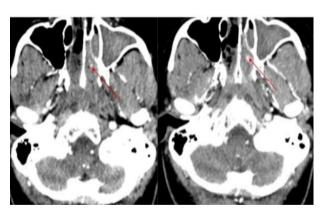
CT angiogram early arterial and delayed phases showing focal small active extravasation of contrast along posterior aspect of left middle meatus.
